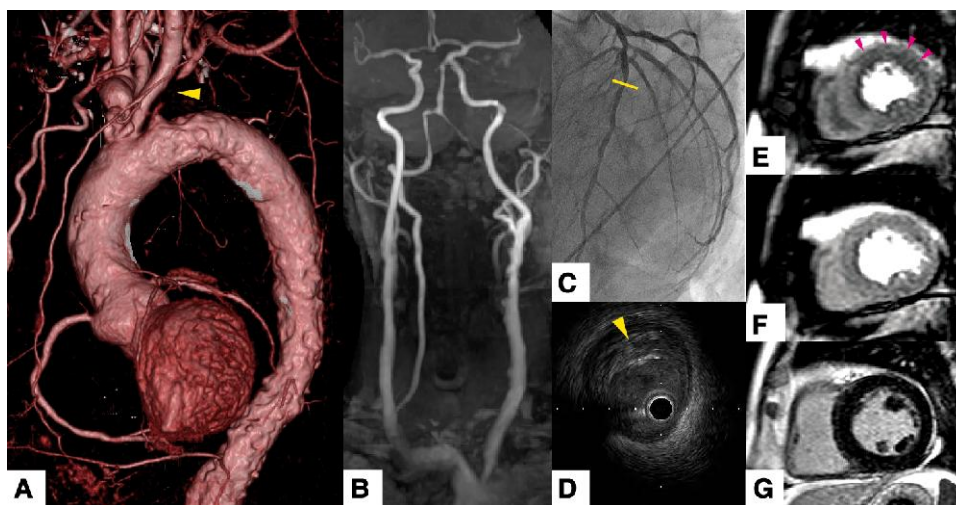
(A) Three-dimension reconstruction of computed tomography showed aortic plaque and left subclavian artery occlusion (arrowhead). (B) Non-contrast enhanced magnetic resonance angiography showed prominent plaque formation, wall irregularities in bilateral common carotid arteries, and occlusion of the left vertebral artery. (C) Coronary angiography in left anterior oblique cranial view showed stenosis in the left anterior descending artery (line). (D) Intravascular ultrasound of the left anterior descending artery confirmed diffuse hypoechoic plaques (arrowhead). (E) Cardiac magnetic resonance of adenosine triphosphate stress perfusion and (F) rest perfusion showed an inducible perfusion defect in extensive anterolateral region (arrowhead). (G) Cardiac magnetic resonance imaging showed no obvious late gadolinium enhancement.
